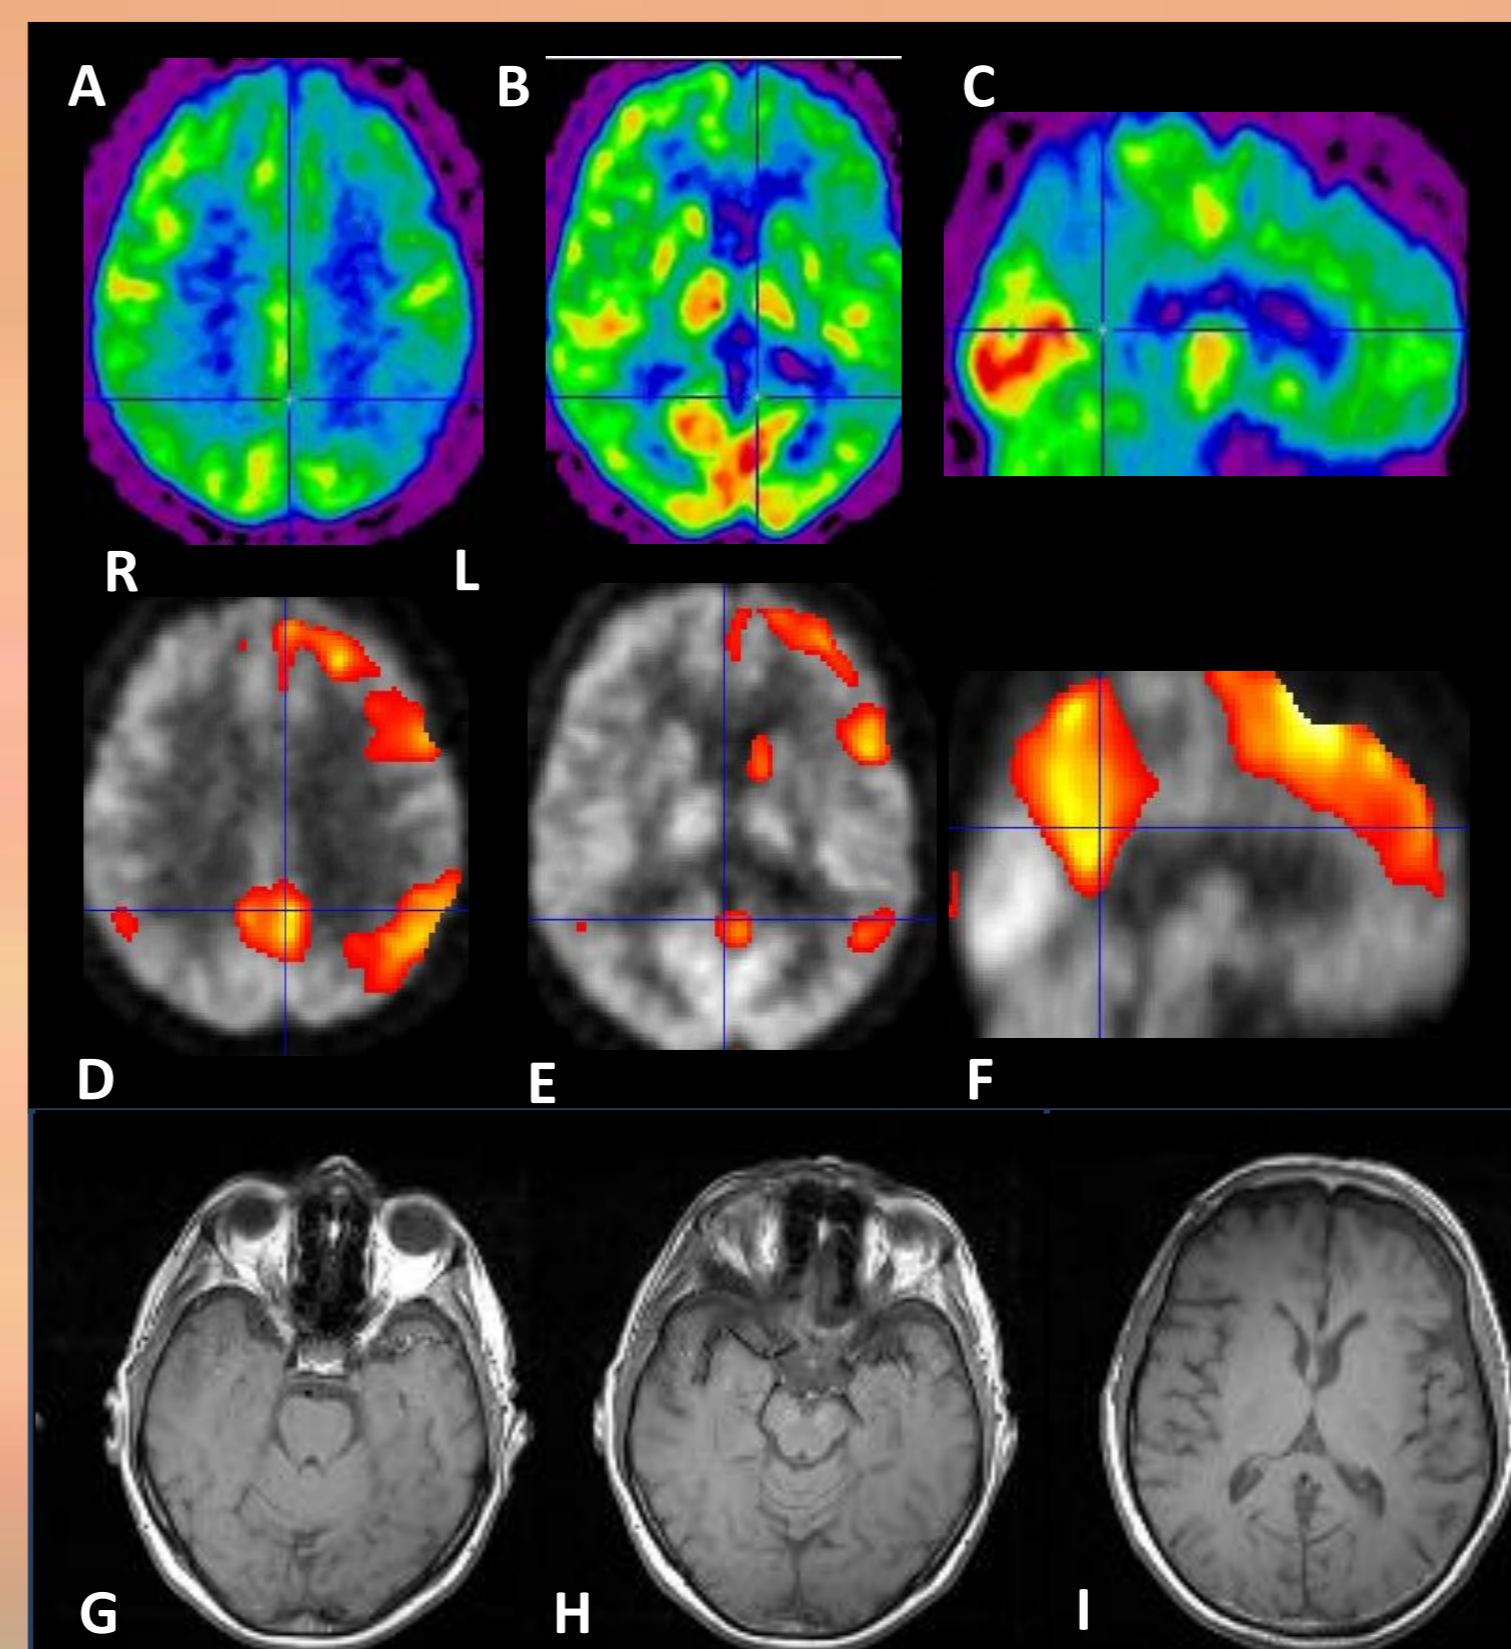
Axial (A,B) and sagittal (C) PET scans in a patient affected by bvFTD show glucose hypometabolism (45-60 mins after ¹⁸FDG injection) in frontal, parietal, temporo-parietal and posterior cingulate cortex (PCC) prevailing on the left. SPM analysis, matched with 16 control subjects, (D, E, F) makes those alterations, in particular in PCC, more evident. T1-weighted MRI images (G, H, I) evidence frontal and anterior temporal atrophy with hippocampal sparing. This patient presented deficits in verbal and spatial memory, behavioural and executive functions, likely due to the pattern of metabolic alterations.
